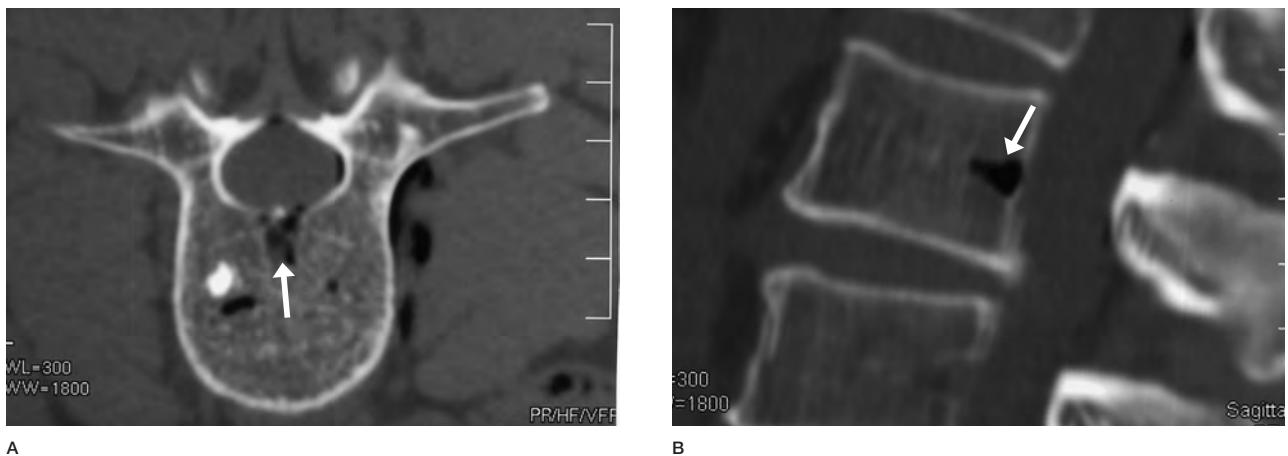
CT image of gas embolism in the basivertebral vein (arrows).
